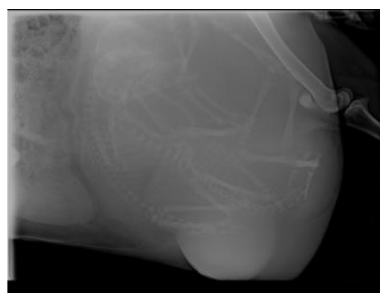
Radiographic view of right lateral lower abdominal region showing fetal skeleton
